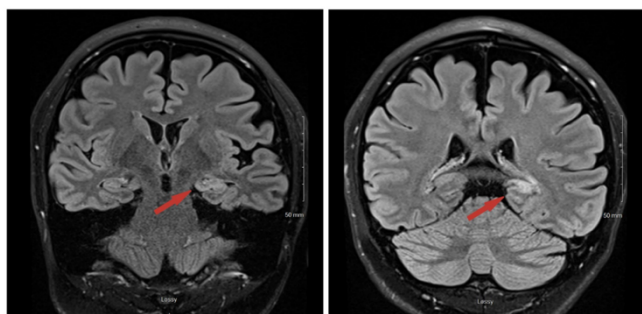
Magnetic resonance imaging (MRI) in our patient. The above images show coronal sections obtained via 7-Tesla MRI (Magnetic Resonance Imaging) brain in our patient. Red arrows point to areas of subtle T2-Fluid Attenuation Inversion Recovery (FLAIR) hyperintensity within the left mesial temporal lobe. These findings are consistent with left mesial temporal lobe sclerosis, a common finding seen in patients with focal epilepsy.
